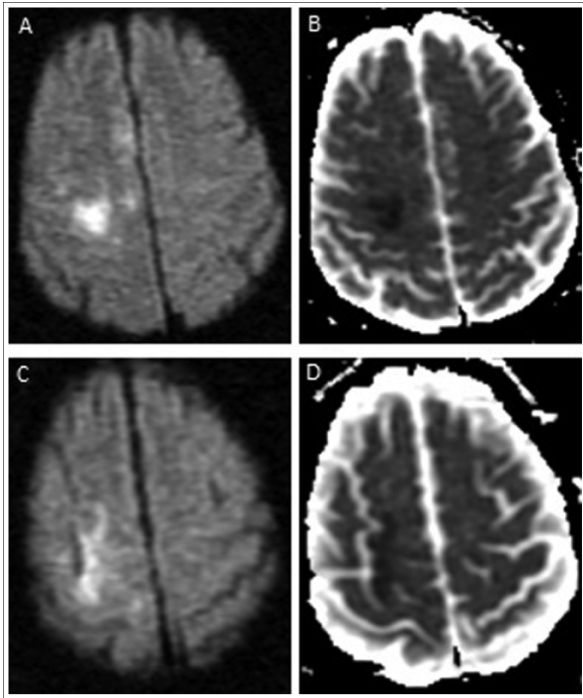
Magnetic Resonance Imaging of the Brain Showing Strokes in the Right Cerebral Hemisphere. Diffusion-weighted (A, C,) and corresponding apparent diffusion coefficient (B, D) images showing multiple small acute lacunar-type infarcts.
